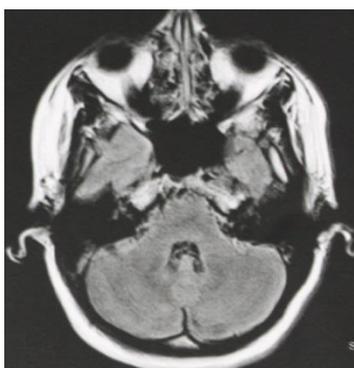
MRI scan in an axial view showing normality.
